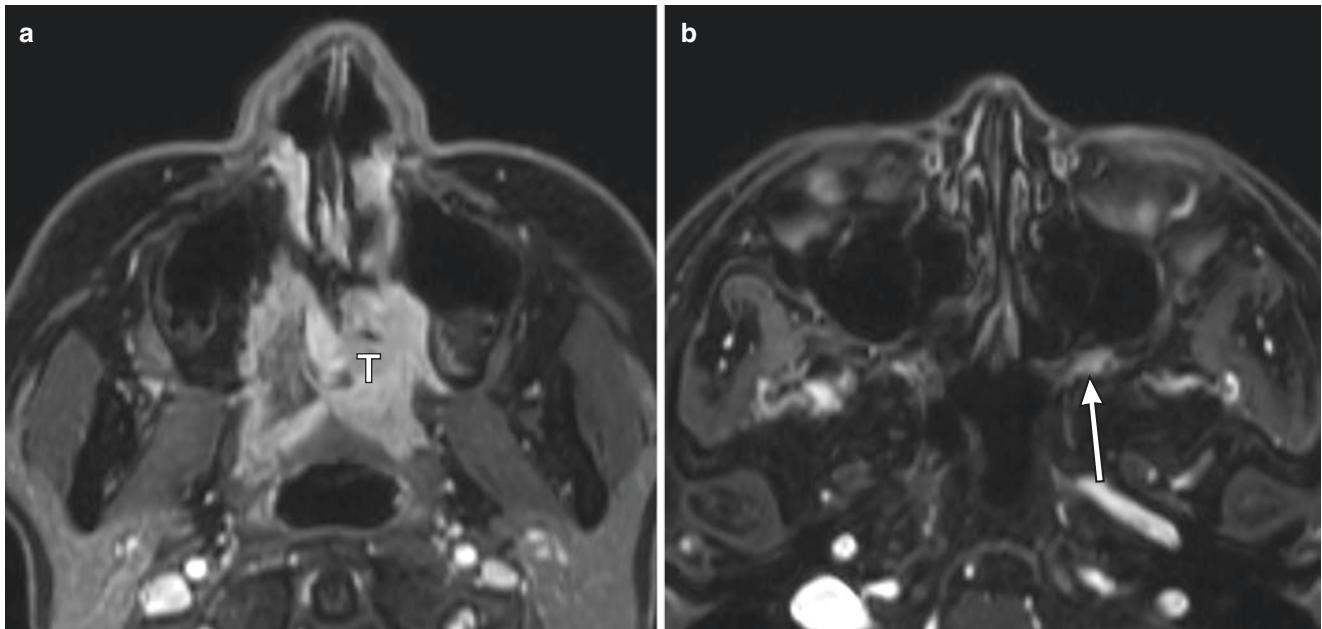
A 57-year-old woman with adenoid cystic carcinoma of the hard plate. (a, b) On post-enhanced T1-weighted image with fat suppression, the tumor (T) in the left hard plate spread to the left pterygopalatine fossa along the second division of the trigeminal nerve (arrow)
